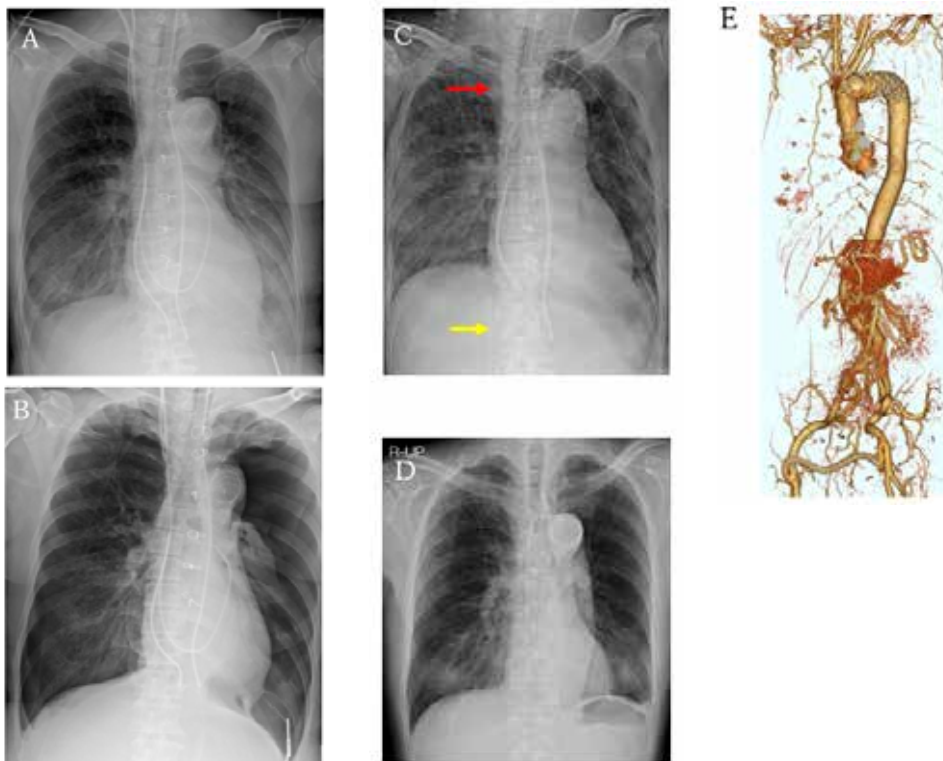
Postoperative chest radiography. (A) Immediately after surgery. (B) Bilateral pneumothorax. (C) When veno-venous extracorporeal membrane oxygenation is introduced. The cannula of outlet flow (red arrow) and the cannula of inlet flow (yellow arrow) are observed. (D) Chest radiograph. (E) 3D-computed tomography image following discharge.
